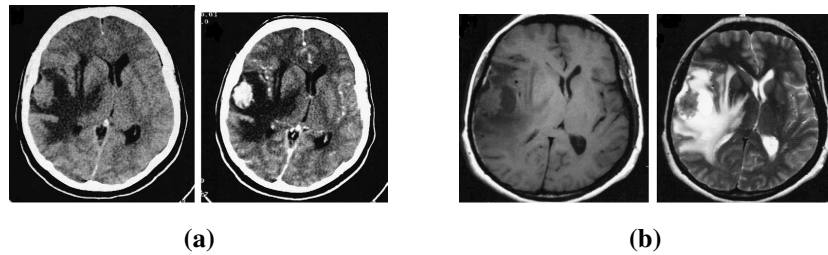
Meningioma imaging. (a) Computerized tomography. (b) Magnetic resonance (T1-weighted MRI on the left, T2-weighted MRI on the right).
